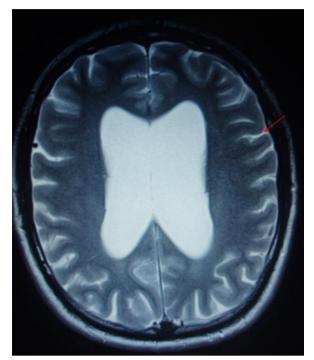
CT scan of a dilated ventricular system
